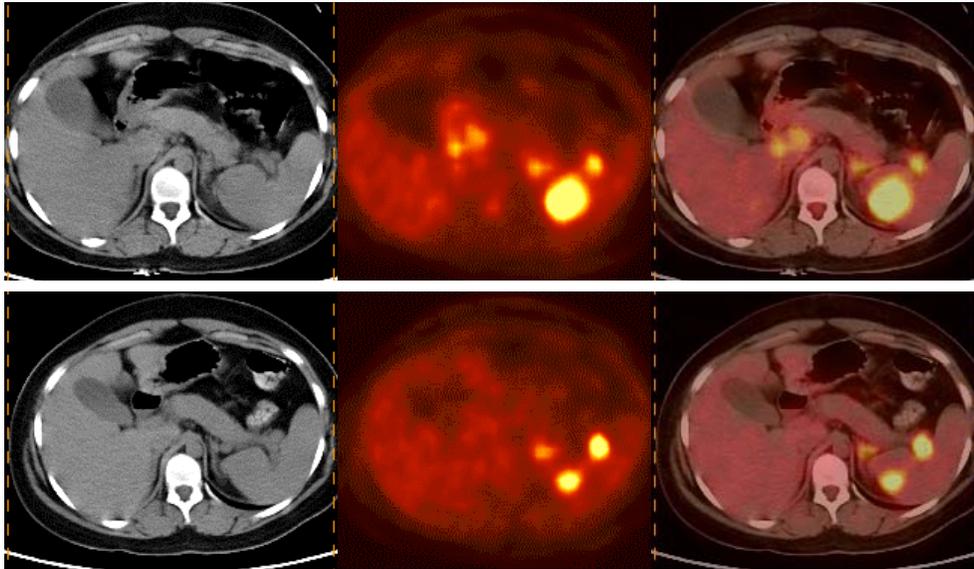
Pretherapy (upper row) and post therapy (lower row) CT, PET and PET/CT scan showing significant response.
